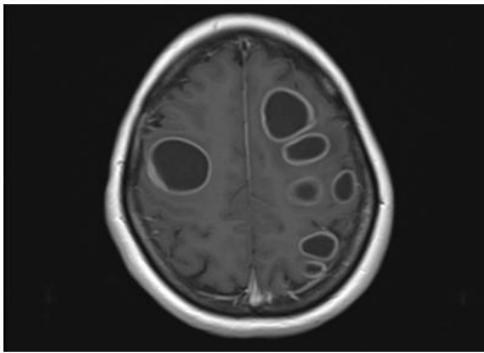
Axial T1-weighted post contrast MRI image demonstrating multiple metastatic lesions. The largest lesion was seen in the Right frontal lobe measuring 31 mm.
